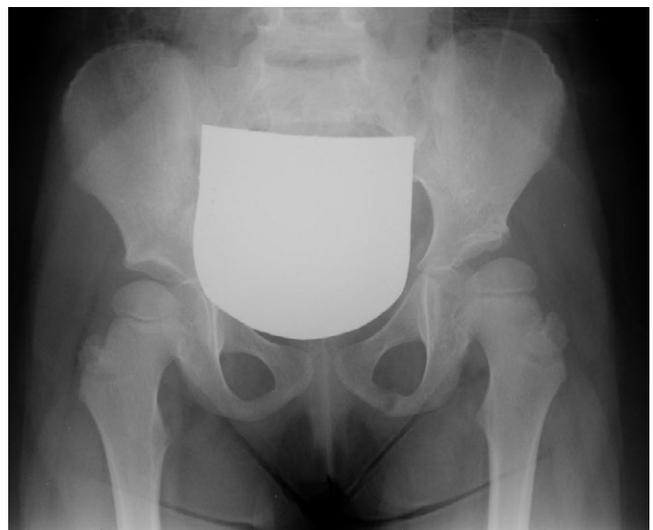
Radiograph at 5 years. There are no signs of avascular necrosis. Acetabular dysplasia is present.
